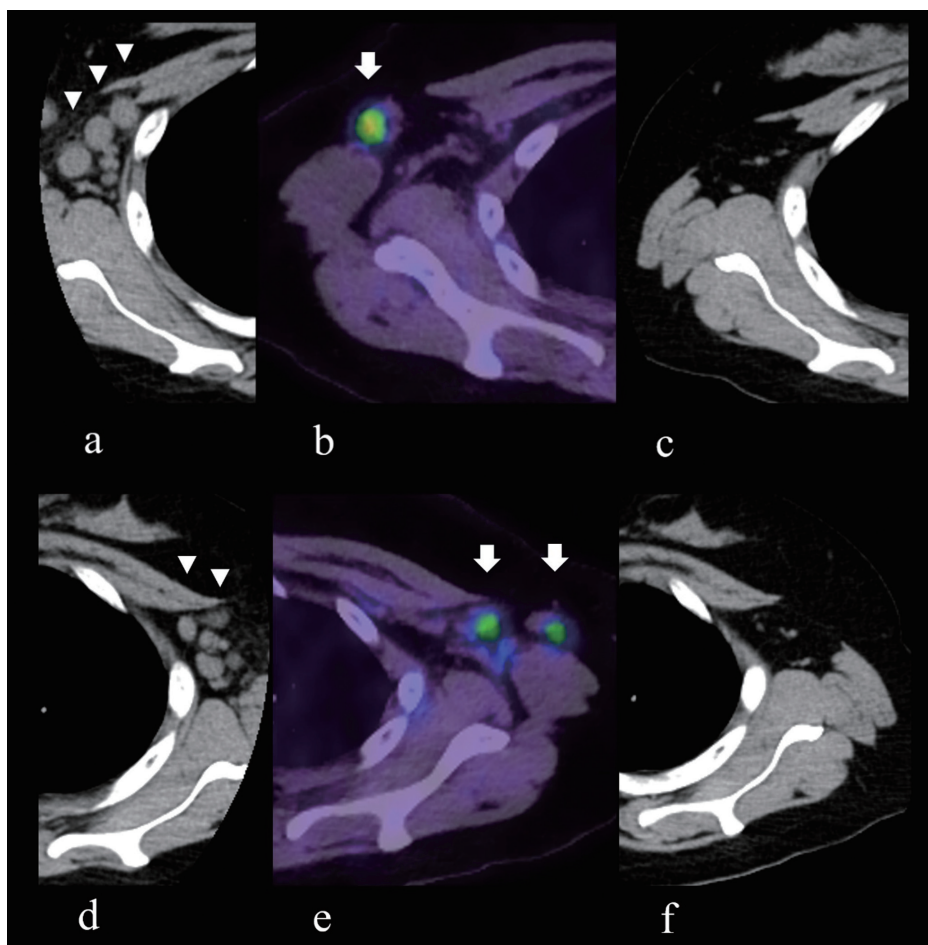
Changes in CT and positron emission tomography (PET)/CT images of axillary lymph nodes in Patient 3. (a) Multiple enlarged lymph nodes in the right axilla (arrowheads) at the time of diagnosis of LPD. (b) Increased accumulation of fluorine 18-labeled fluorodeoxyglucose in the right axillary lymph node (arrow), but smaller size than 10 days prior. (c) The lymphadenopathy in the right lung has completely disappeared 7 months after discontinuation of MTX. (d) Multiple enlarged lymph nodes in the left axilla (arrowheads) at the time of diagnosis of LPD. (e) Increased accumulation of fluorine 18-labeled fluorodeoxyglucose in the left axillary lymph nodes (arrows), but smaller size than 10 days prior. (f) Lymphadenopathy in the left lung has completely disappeared 7 months after discontinuation of MTX.
